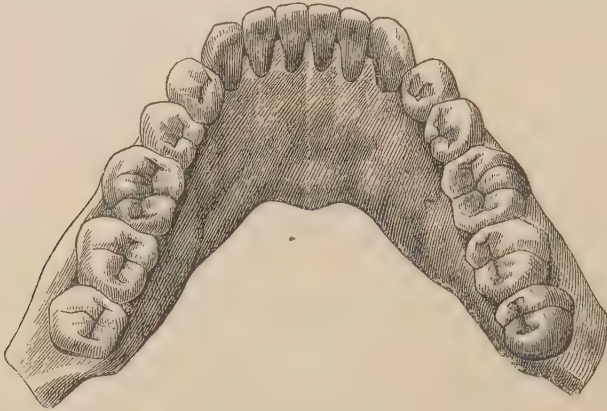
UPPER ASPECT OF LOWER DENTAL ARCH AND BODY OF LOWER JAW. (Mühlreiter.)
